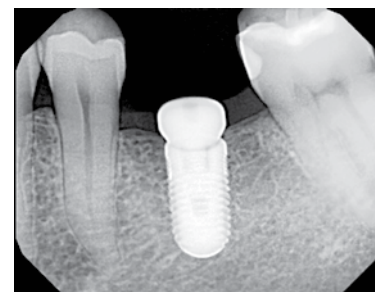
Radiograph shows another Inclusive Tapered Implant six months post placement with positive bone height after healing.
